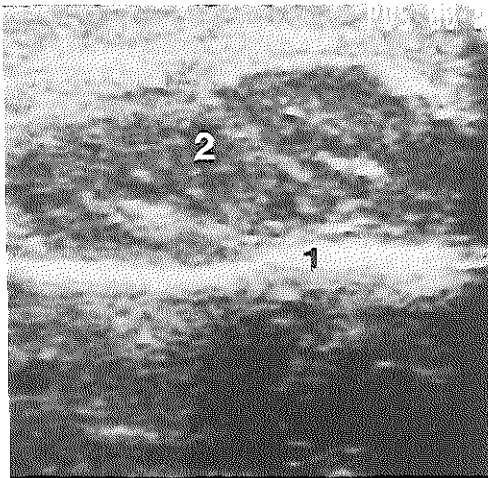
Ultrasound view parallel to the mandible (1). The masseteric muscle (2) is enlarged.
